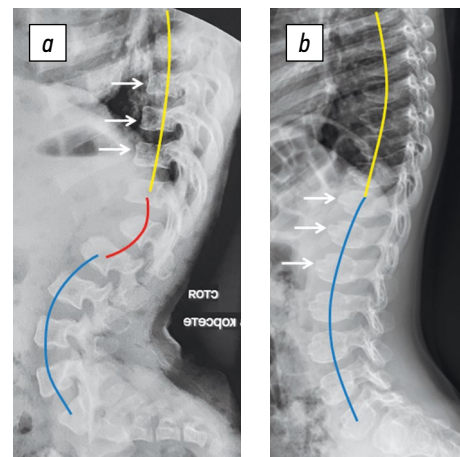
Radiographs of the thoracic and lumbar spine in the lateral view of patients with achondroplasia (a) and pseudoachondroplasia (b): a, physiological ossification of the apophyses of the vertebral bodies with square contours of the vertebrae (white arrows), flattened thoracic kyphosis (yellow line), pathological thoracolumbar kyphosis (red line), and enhanced lumbar lordosis (blue line); b, abnormal ossification of the apophyses of the vertebral bodies with linguiform protrusions of the anterior parts of the vertebrae (white arrows), physiological value of thoracic kyphosis (yellow line), and moderate increase in lumbar lordosis (blue line)
